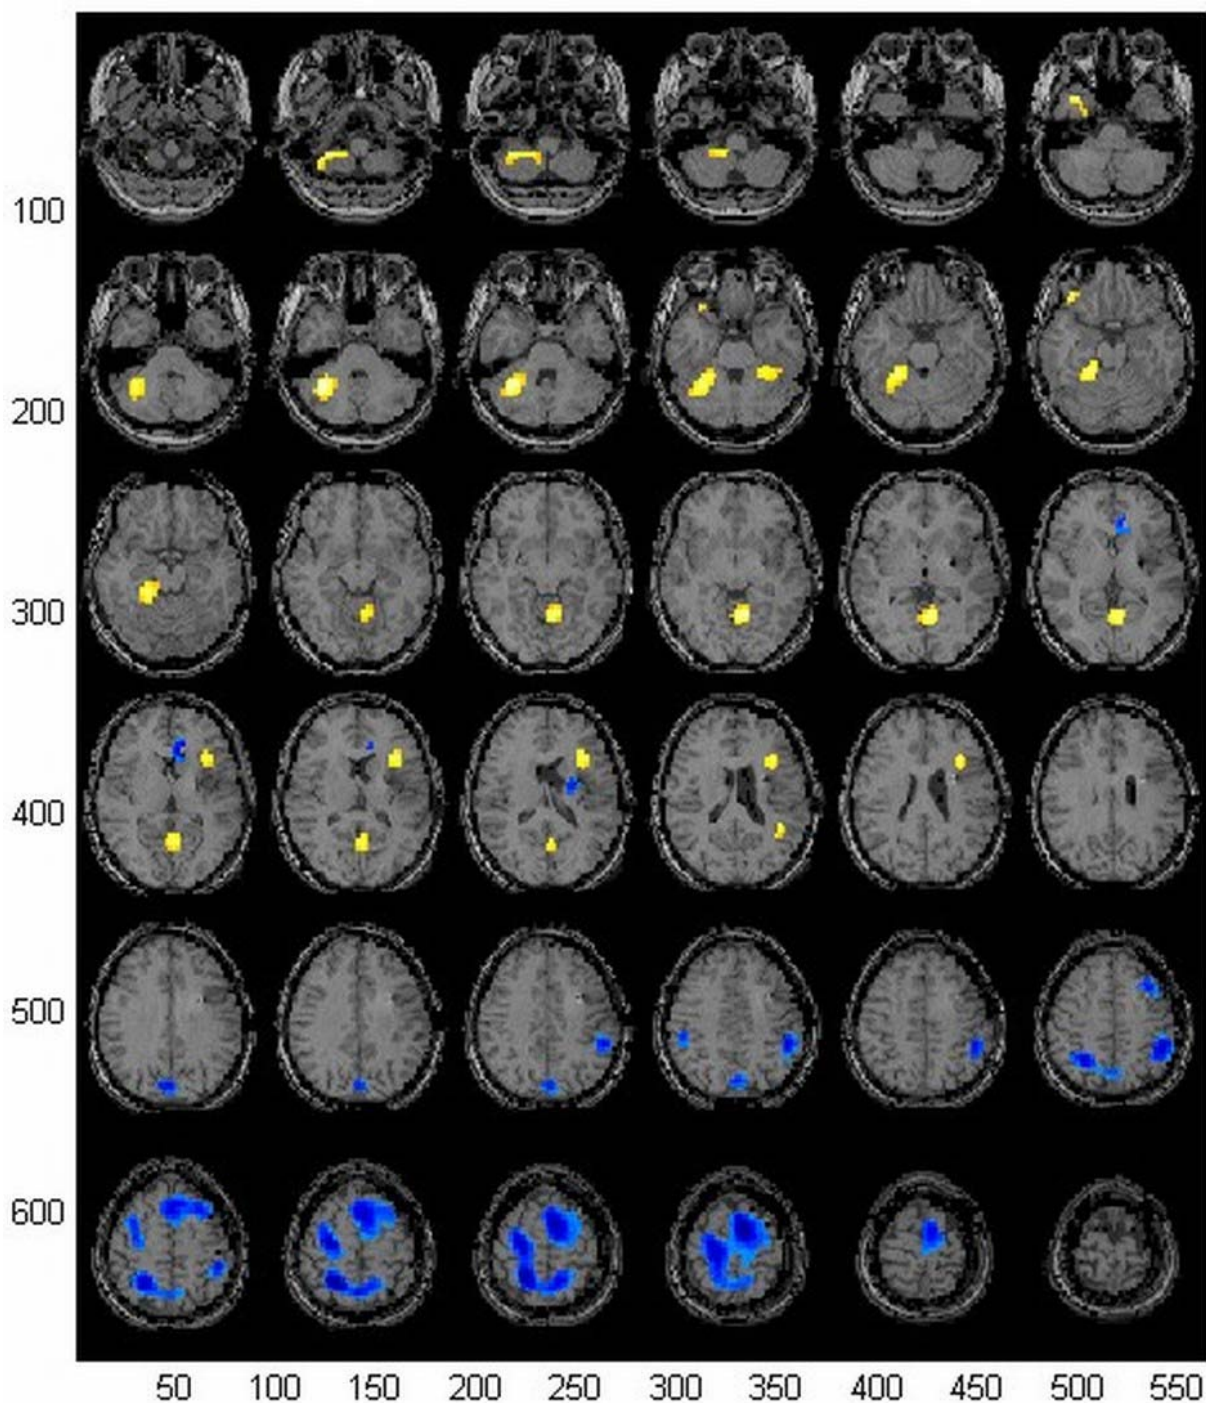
SISCOM analysis comparing déjà vu-eliciting stimulation (ictal) the normal (interictal) SPECT superimposed on axial MRI scans. (yellow: hyperperfusion, blue: hypoperfusion). Compared to the baseline, SPECT during DV showed right-sided hyperperfusion of hippocampus, parahippocampal gyrus, fusiform gyrus, cerebellum and temporal superior pole left-sided hyperperfusion appeared in the cerebellum, operculum, insula, lingual gyrus, precuneus and middle temporal gyrus. Hypoperfusion appeared bilaterally in the precentral and postcentral gyri, as well as, in the frontal (especially supplementary motor cortex) and parietal areas.
